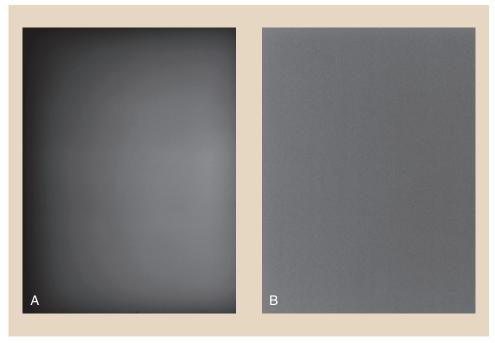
A, Exposure to a raw x-ray beam shows the heel effect on the image. B, Flat-fielding corrects this defect and makes the image receptor response uniform. (Courtesy Anthony Siebert, University of California, Davis.)
